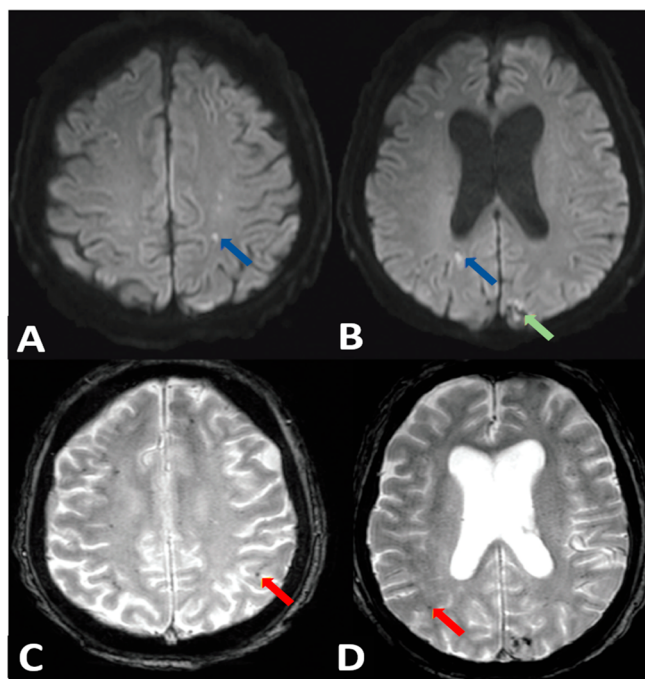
MRI images from 61-year-old man with COVID-19: (A, B) acute infarcts within the bilateral cerebral white matter (blue arrows) and left occipital hemorrhagic infarct (green arrow) (images obtained using axial diffusion sequence); (C, D) innumerable microhemorrhages throughout the bilateral cerebral hemispheres (red arrows) (images obtained using gradient-echo sequences). Copyright permission was obtained to reproduce Figure 1 from the publisher.³
